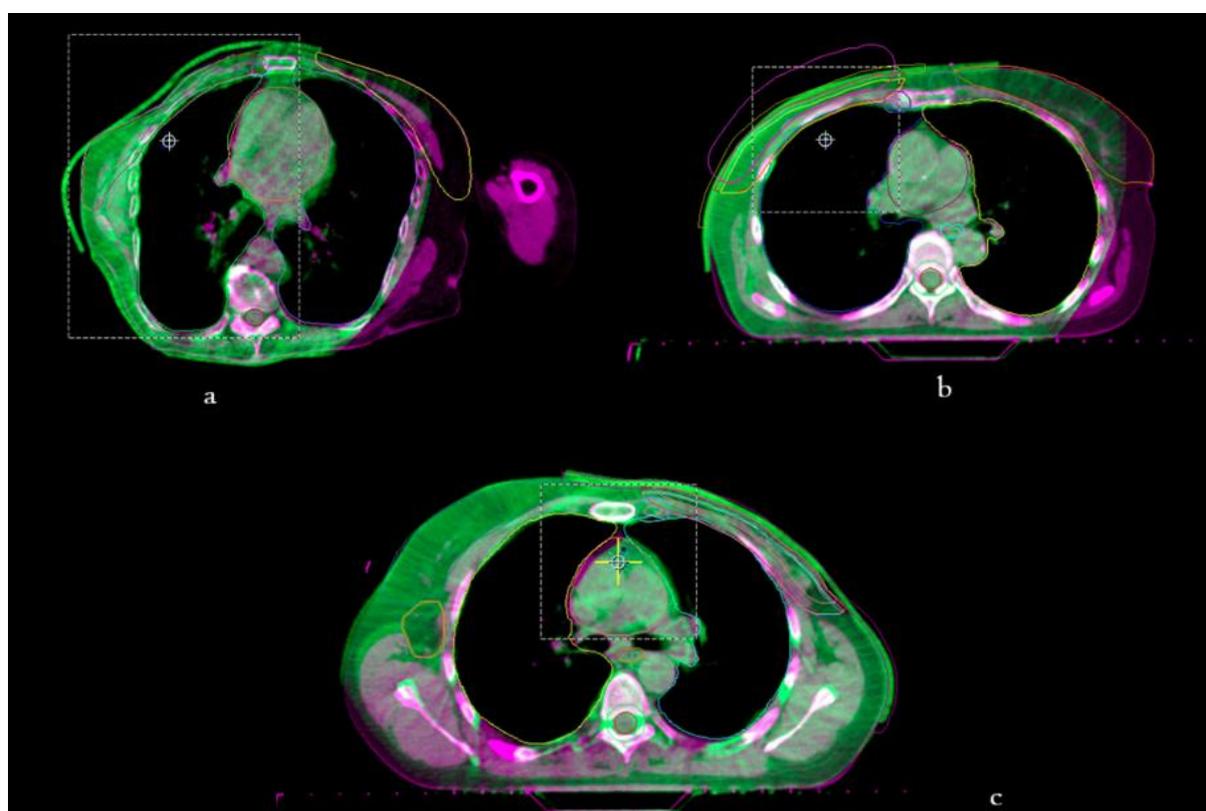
4 Fused CBCT and CT clinical images demonstrating the significance of maintaining a regular contour and planar surface in the patient's exposed region. (a) The patient's chest wall with a non-planar surface results in the formation of air-gaps; (b, c) A planar surface allows for optimal adherence of the bolus material to the skin, minimizing air gaps and ensuring effective dose delivery.
